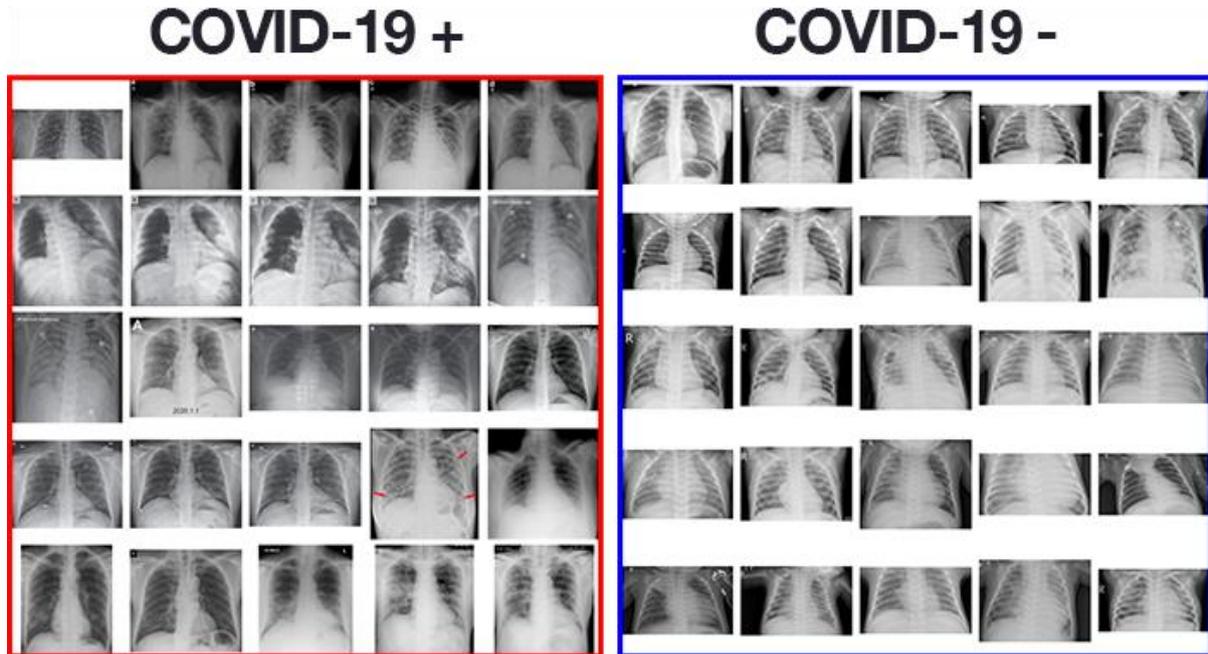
COVID19 Chest X-Ray Dataset, Left is COVID19 positive and Right is COVID19 negative
